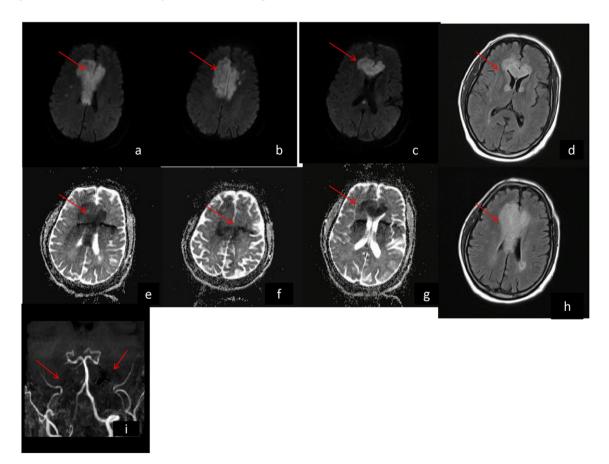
Brain MRI DWI (a), (b) & (c) showing diffusion restriction in genu, body and splenium of CC (red arrows); FLAIR axial view (d) & (h) showing hyperintensity in genu, body and splenium of CC (red arrows); brain MRA showing non-visualization of both ICA with thinning of right vertebral artery (red arrow).
